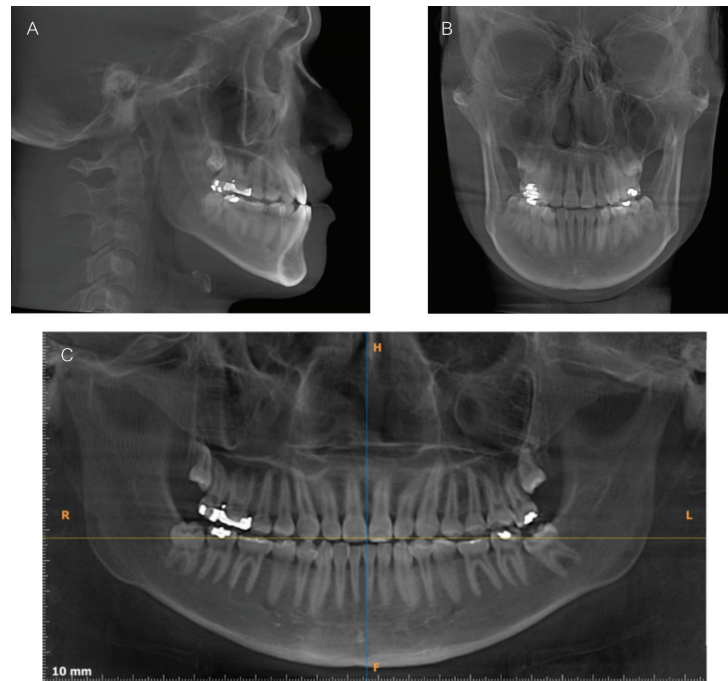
Pre-treatment (A) reformatted lateral view, (B) reformatted antero-posterior view, and (C) reformatted panoramic radiograph.
